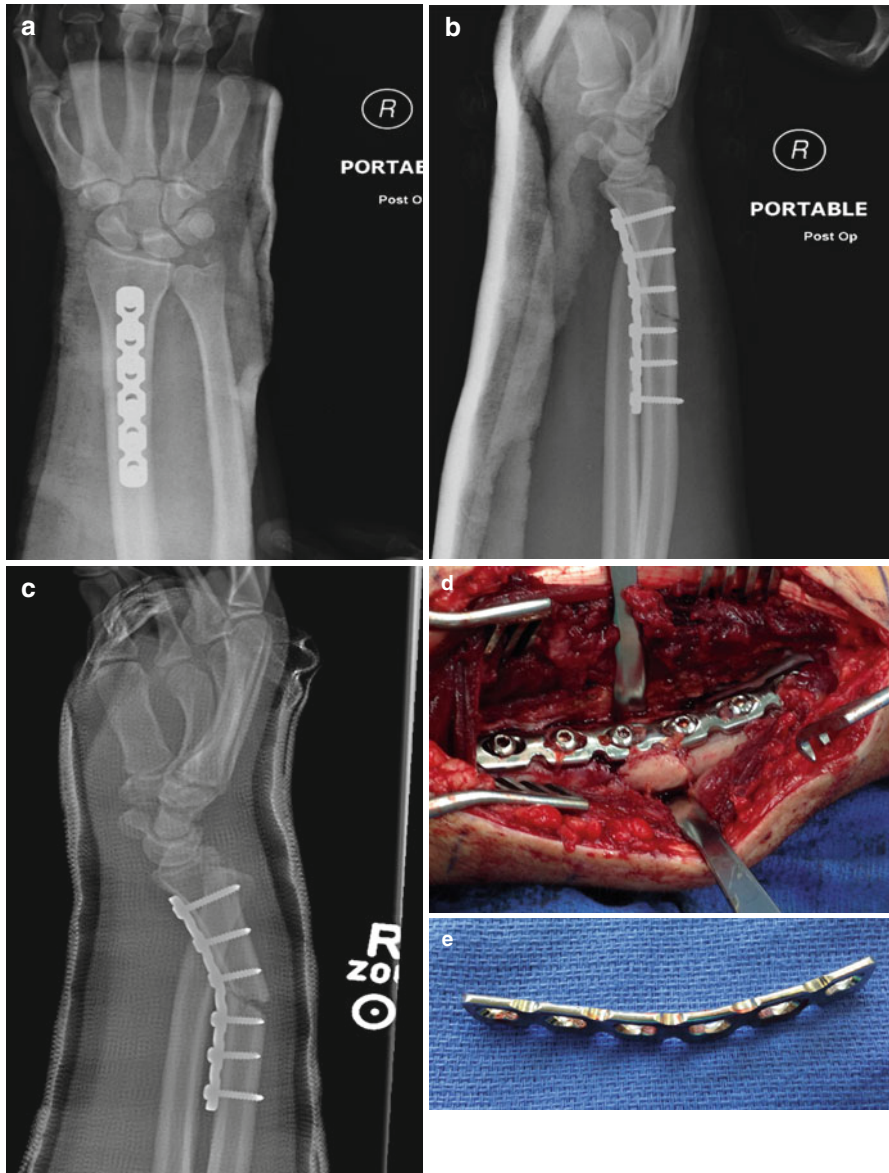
This radial shaft fracture was treated by open reduction and internal fixation, however the surgeon made a judgment error in using a malleable reconstruction plate that was not sufficiently rigid to resist the muscular forces acting on the forearm. (a) Anteroposterior post-operative radiograph. (b) Lateral postoperative radiograph. (c) At 2 weeks post-operatively, the plate has bent and the fracture has angulated despite being protected in a cast. (d) The patient had to undergo an unneeded 2nd revision surgery for removal of the reconstruction plate and revision fixation with a more appropriate compression plate. (e) Photograph of the deformed reconstruction plate
